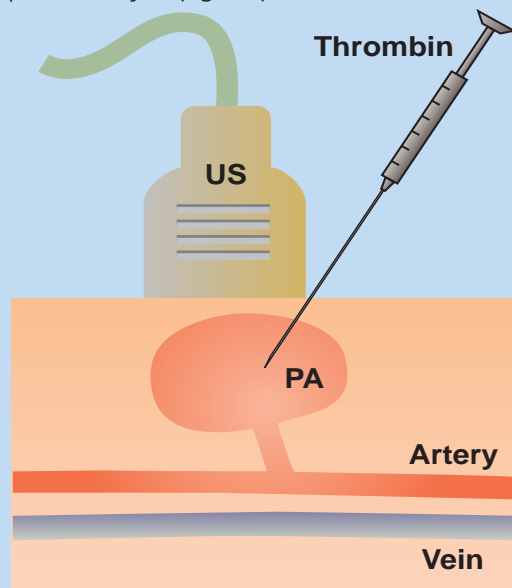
Ultrasound-guided puncture of pseudoaneurysm.
